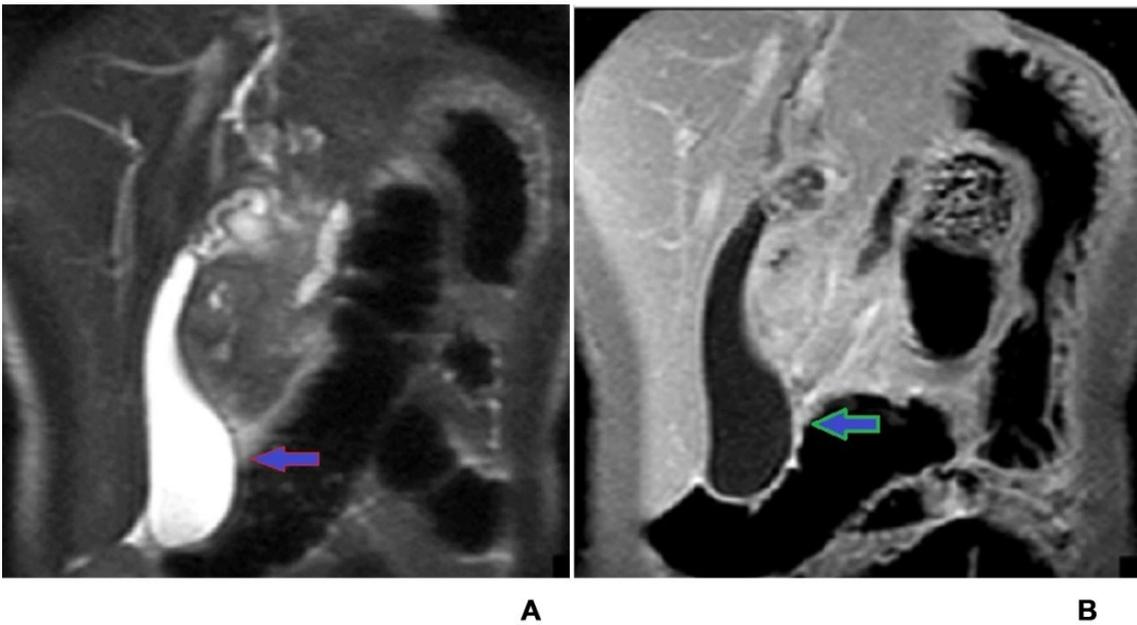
Coronal single-shot fast spin-echo T2-weighted (A), and coronal fat-suppressed contrast-enhanced spoiled gradient-echo (B), images reveal banana-shaped gallbladder.
